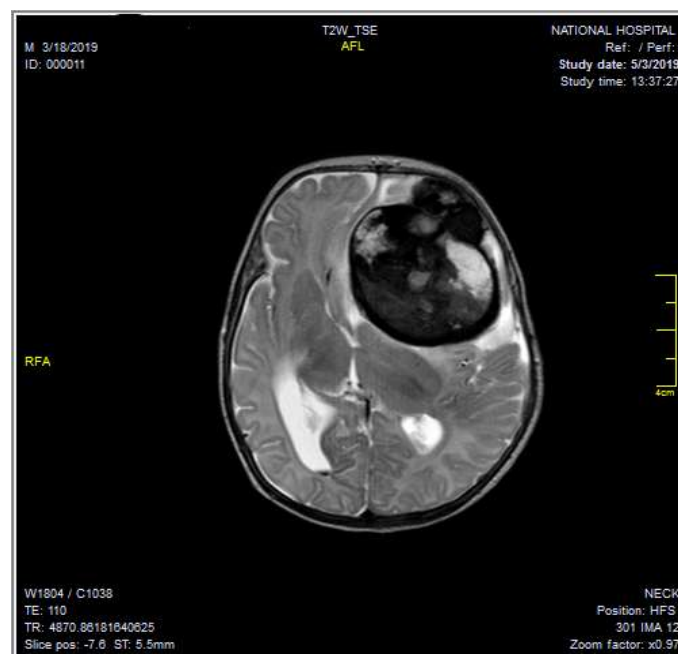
An axial T2-weighted magnetic resonance image of the same patient showing the lesion as a heterogeneously hyperintense left frontal lobe mass with hypointense capsular rim.
